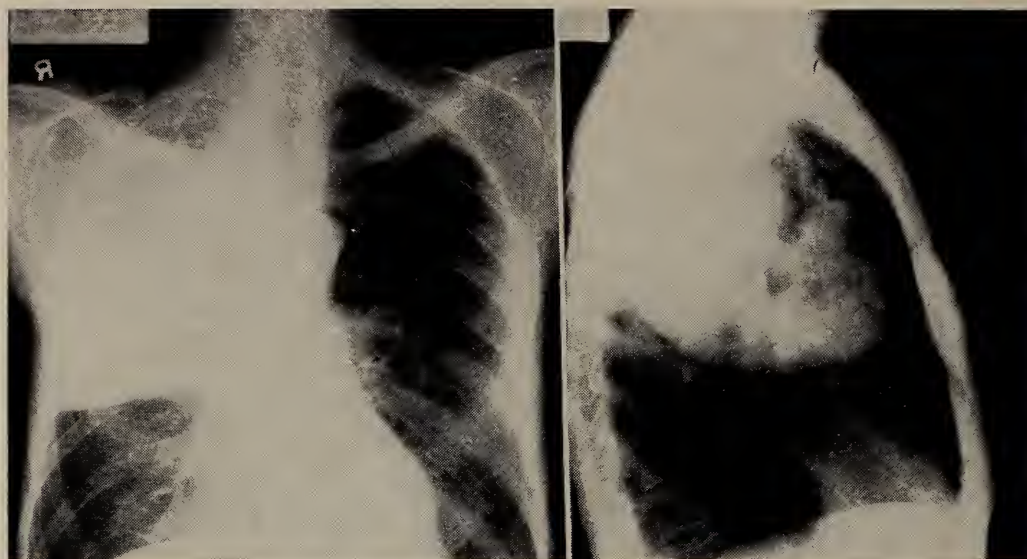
Massive involvement of R U L with alveolar carcinoma. Patient suffered with painful osteoarthropathy and daily temperature elevations for two months before chest x-rays were obtained.
